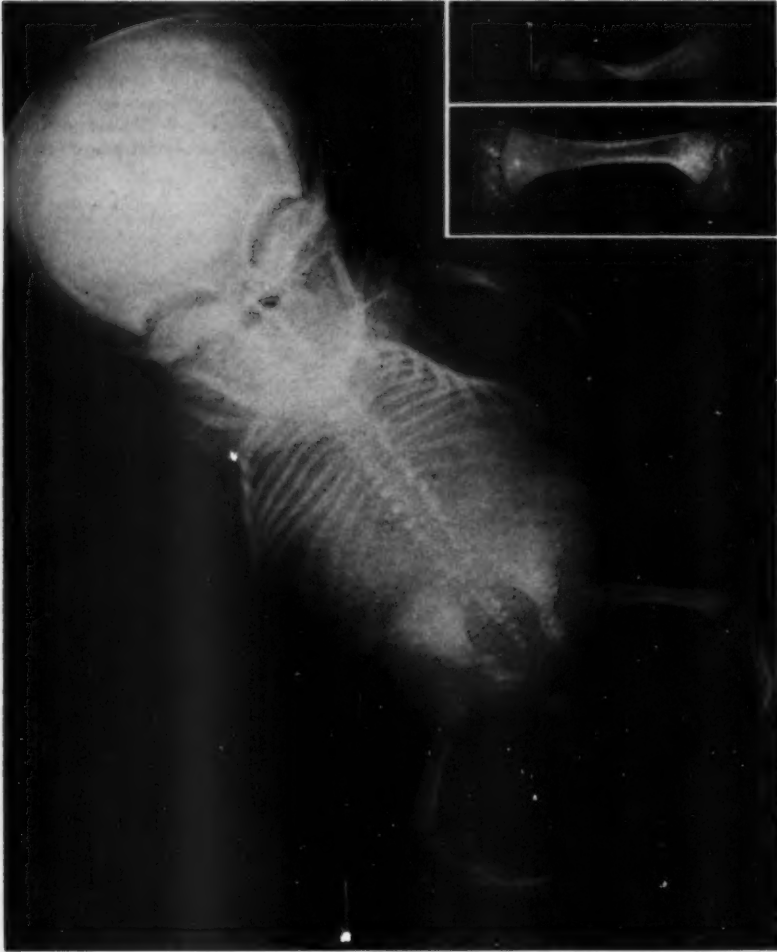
(Case 1).—Roentgenogram showing diffuse stippling of primary and secondary preosseous cartilages, with marked involvement of spinal column. Femora and tibiae also shortened. Inset, roentgenogram of long bones individually dissected showing distribution and nature of calcific particles within cartilage. Contour of cartilage heads is not distorted.
